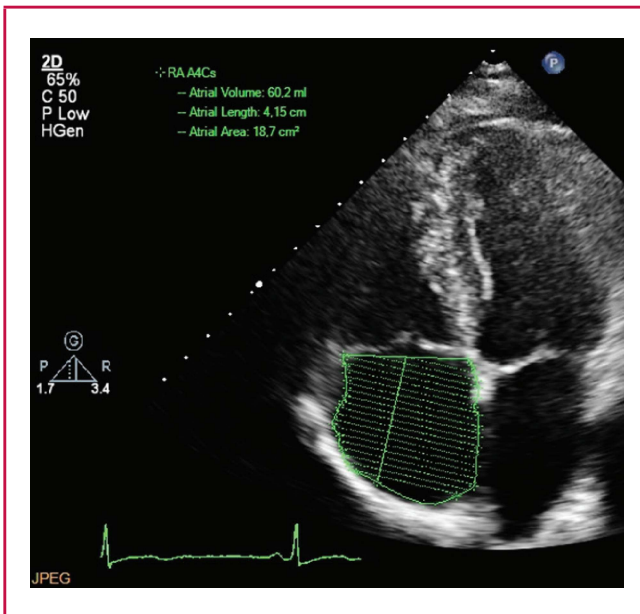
Apical four-chamber view in a normal participant, showing measurement of RA volume using the discs method.
